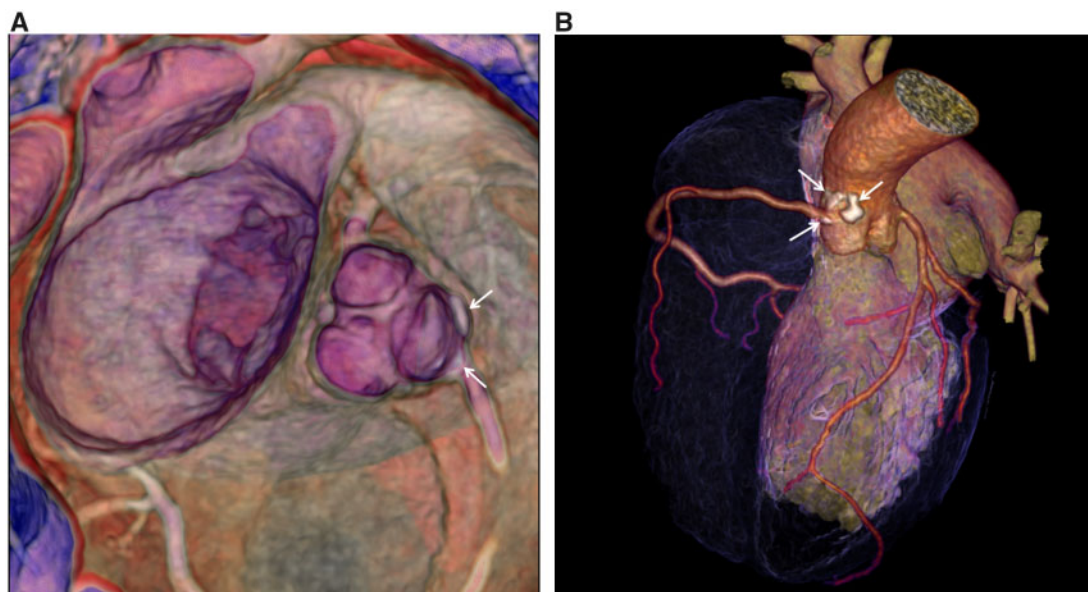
(A and B) Coronary computed tomography angiography. Coronary computer tomography angiography (January 2018) showing a calcified plaque ostially in the right coronary artery, indicated by arrows. Picture by Anders Svensson, Department of Radiology, Karolinska University Hospital, Stockholm, Sweden.
